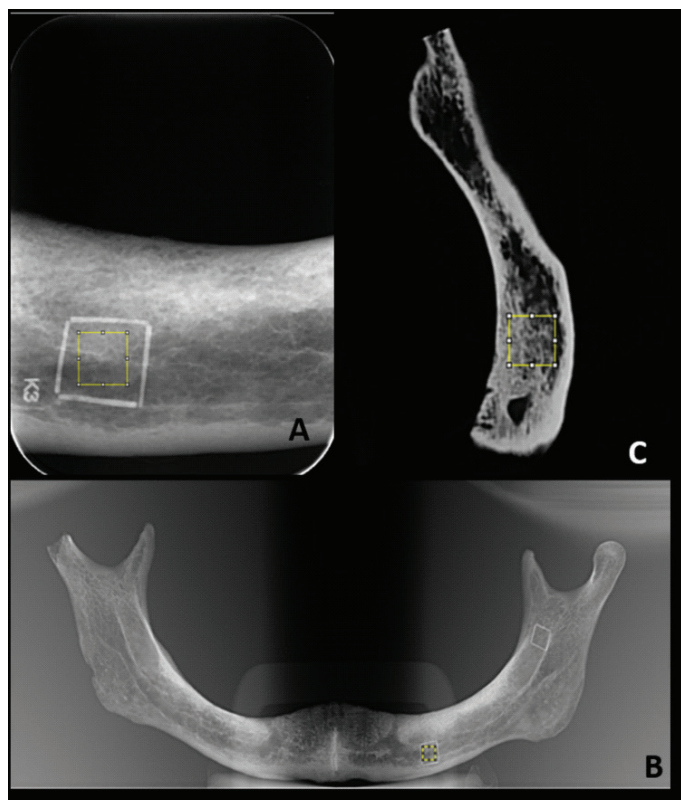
A; periapical radiograph with a 70x70 ROI inserted within the marked area borders, B; panoramic radiograph with a 50x50 ROI inserted within the marked area borders, C; CBCT images with 40x40 ROI inserted within the marked area borders.
